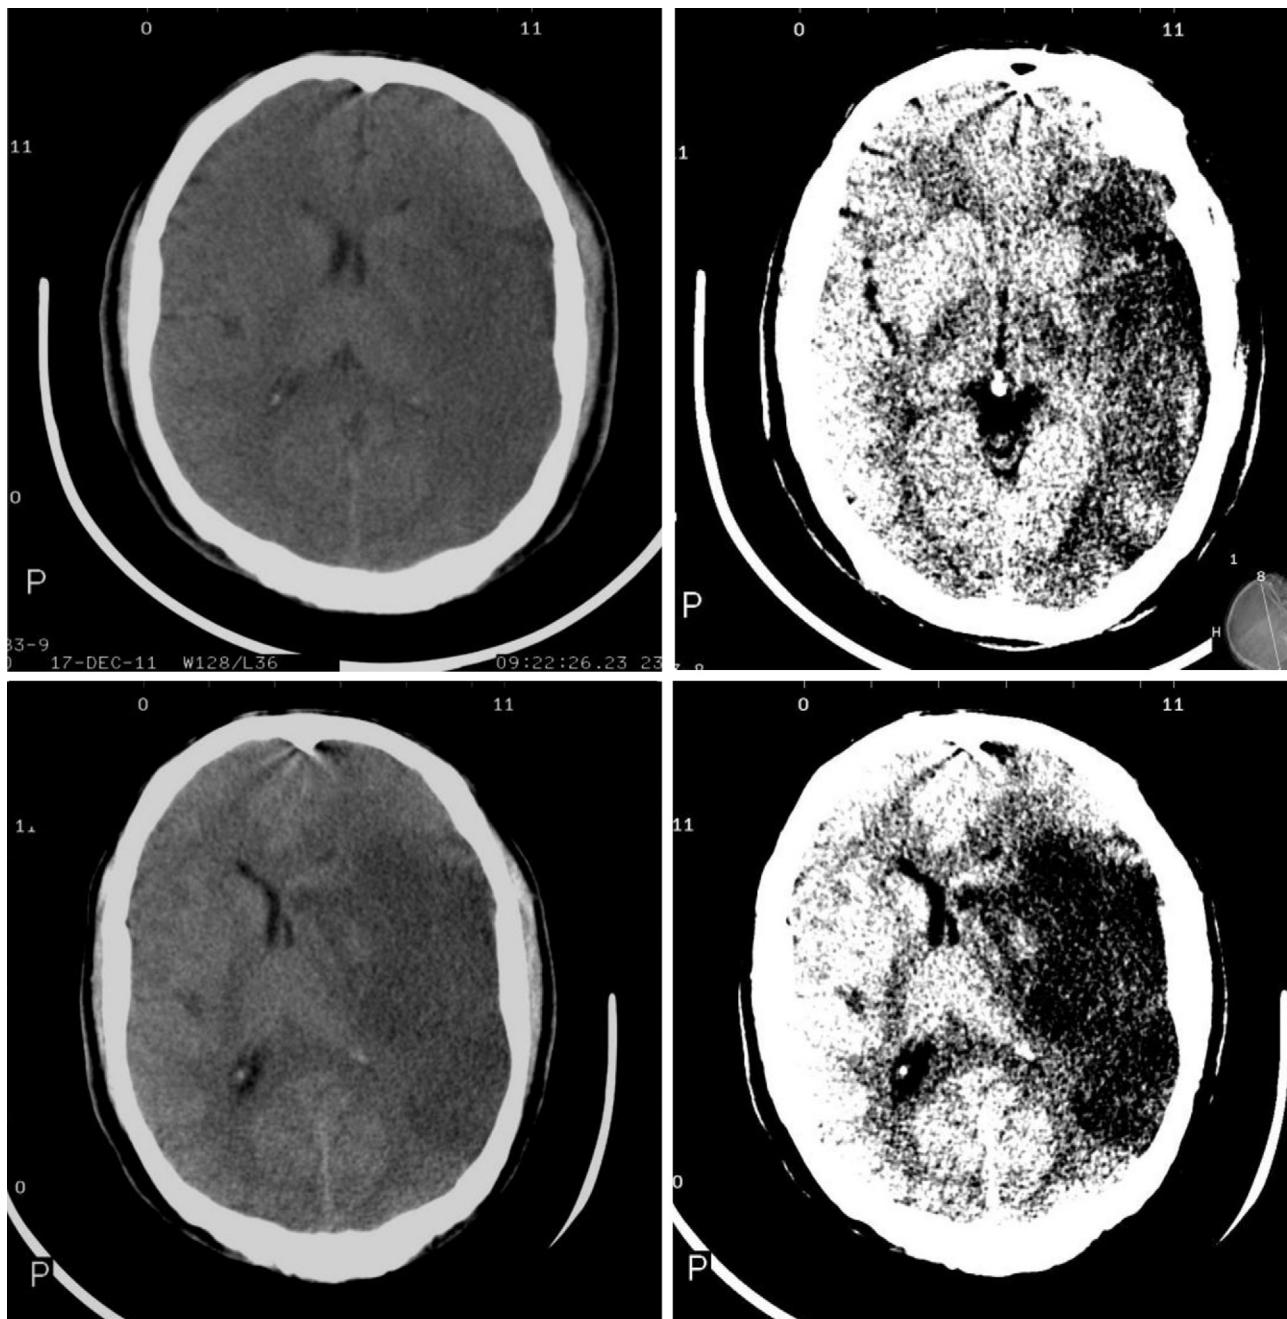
CT scan of a patient with MHI affecting more than 50% of the MCA territory, and midline shift.
